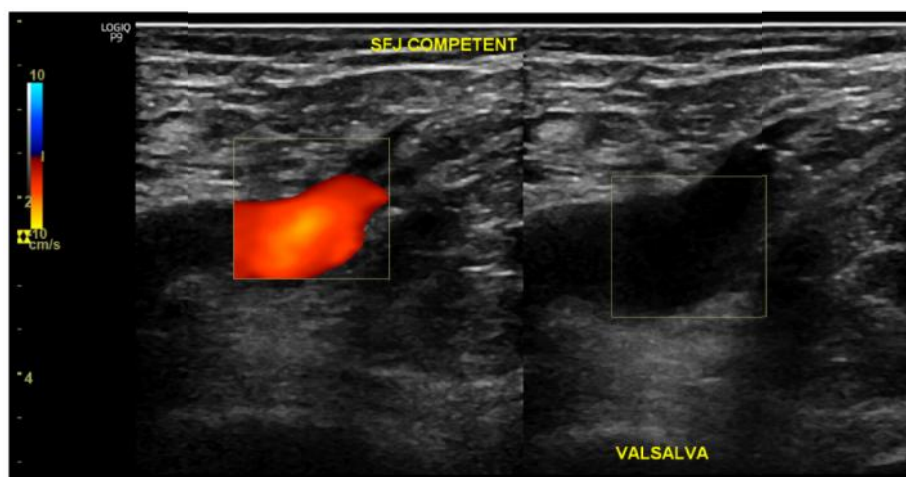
USG Doppler image showing sapheno-femoral junction competence.
